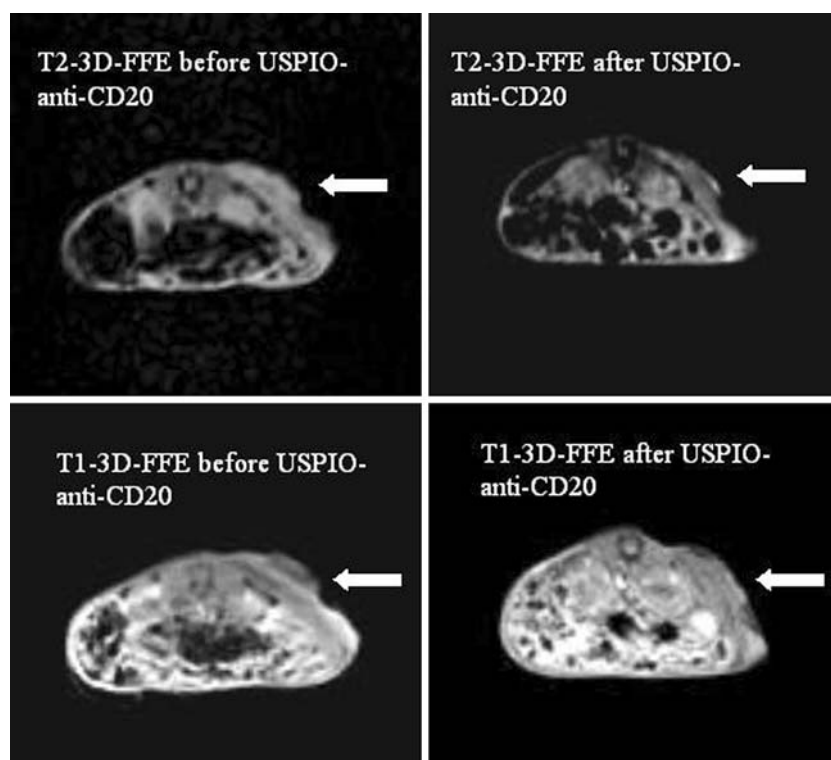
On T2-weighted three-dimensional fast field echo images after USPIO-anti-CD20 antibody administration the CD20high D430B tumor showed an inhomogeneous decrease in signal intensity (*arrows*). On T1-weighted three-dimensional fast field echo images obtained after USPIO-anti-CD20 antibody administration, the CD20high D430B tumor showed an inhomogeneous SI enhancement (*arrows*). T2-weighted three-dimensional fast field echo sequences = T2-3D-FFE (50/12/with flip angle7°). T1-weighted three-dimensional fast field echo sequences = T1-3D-FFE (17/4.6/with flip angle13°). USPIO ultrasmall superparamagnetic particle iron oxide, SI signal intensity
